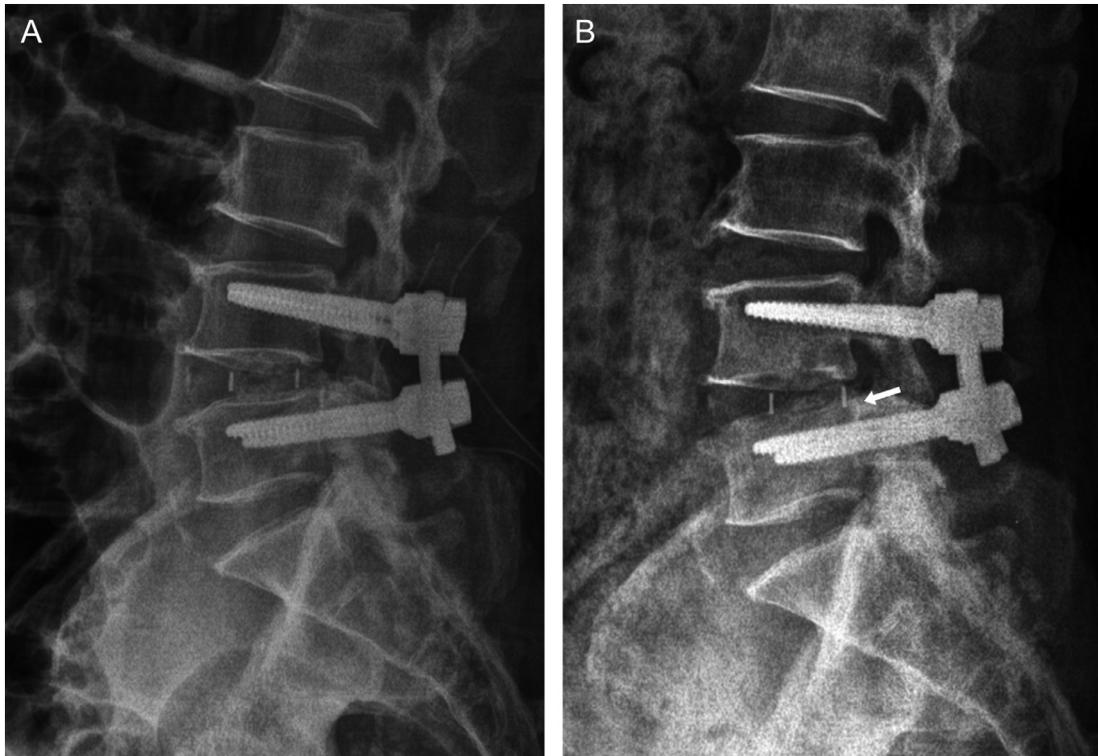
A case showing cage migration with subsidence following TLIF. (A) Immediately postoperative radiograph showing the size and location of both cages is appropriate. (B) Three months after surgery, the cage migrated with subsidence.
